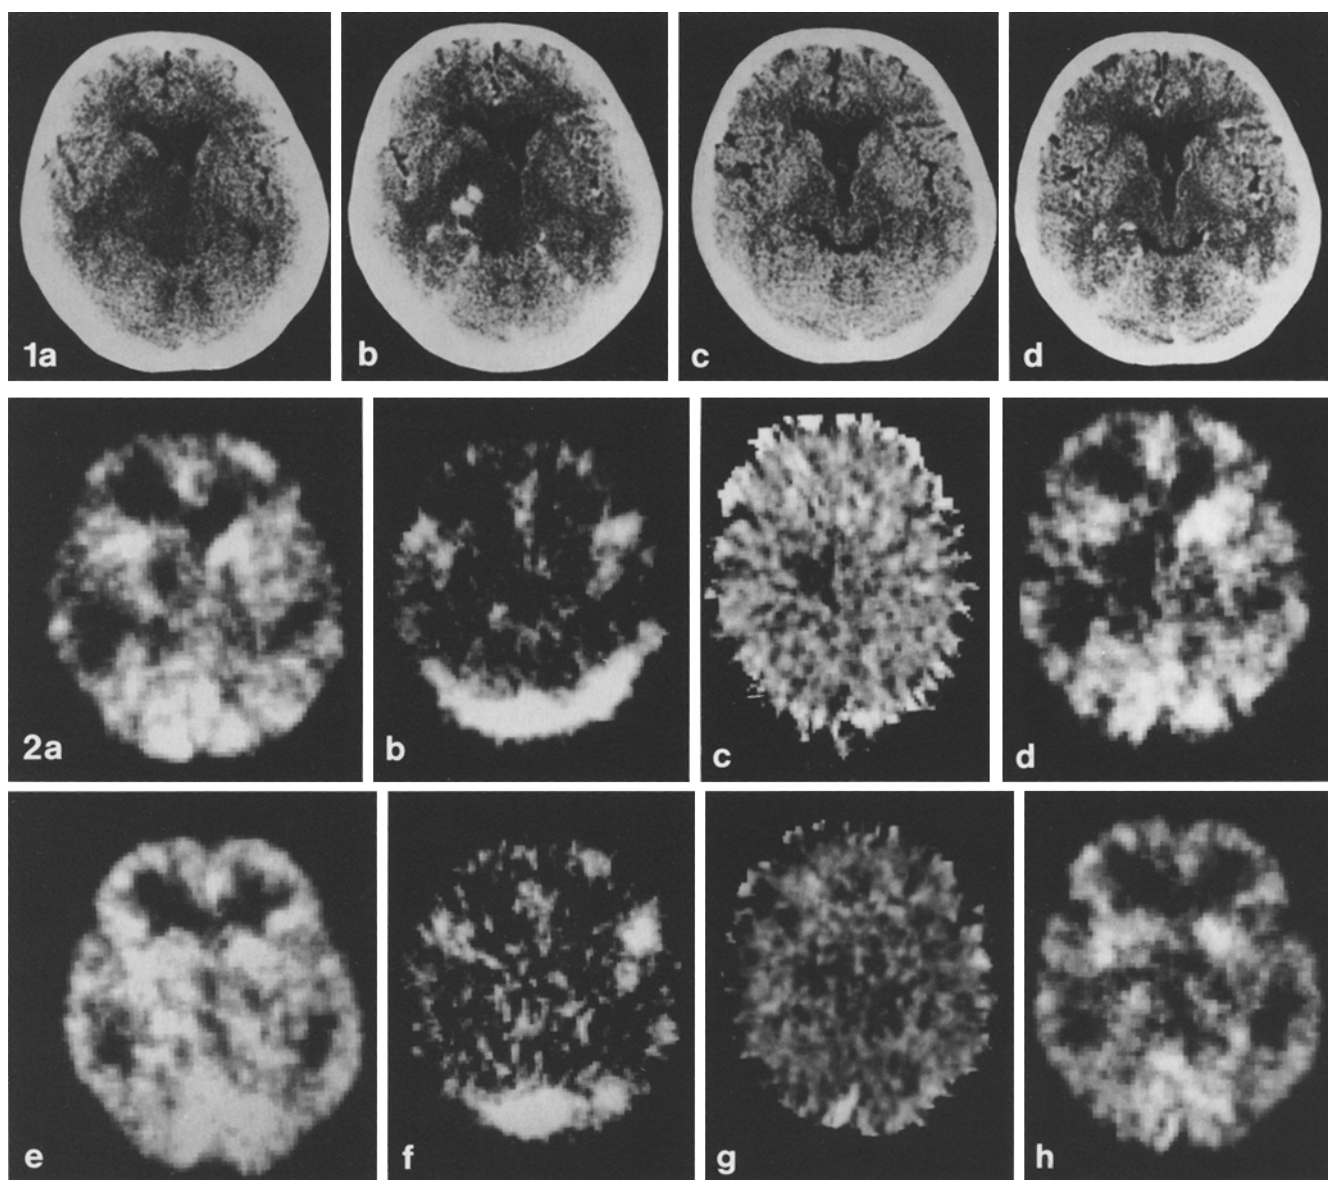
CT scans on admission (a, b) showed a low-density area (LDA) of the right thalamus, extending to the basal ganglia and midbrain with enhancing lesions in the vicinity of the posterior limb of the internal capsule. The LDA and the enhancing lesions disappeared 3 months after completion of steroid therapy (c, d). (Left: Plain CT; right: enhanced CT)
